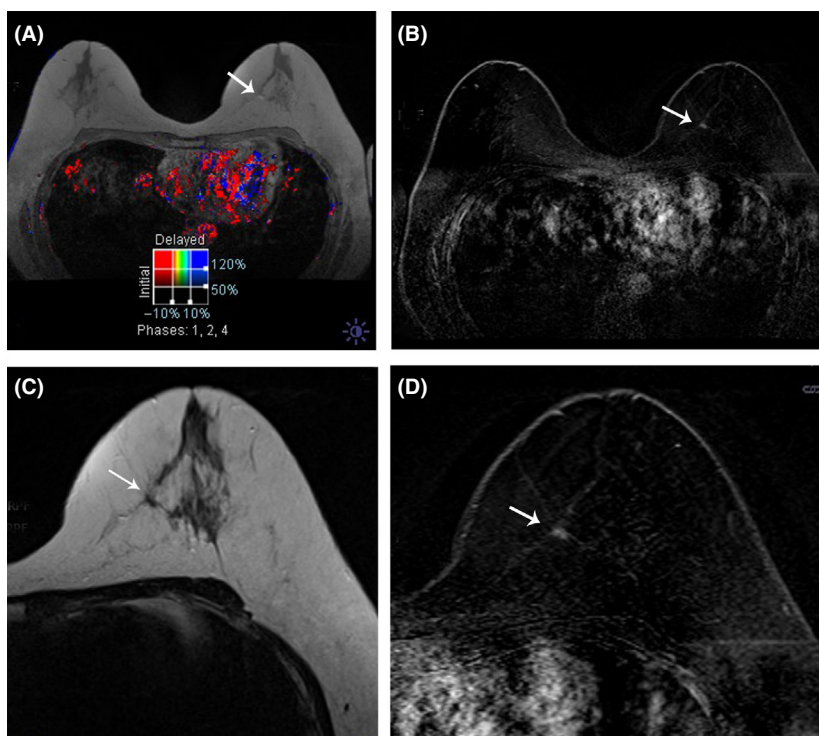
Follow-up MRI 6 months later: (A) colour map first post-contrast T1-weighted image; (B) first post-contrast subtraction; (C) enlarged T2-weighted image of left breast; and (D) enlarged first post-contrast T1-weighted subtraction image. The previously noted focus of enhancement in the lower inner quadrant of the left breast (arrow) was thought to be unchanged. Routine annual follow-up MRI was recommended. In retrospect, this focus has irregular margins and shape and is slightly larger.
